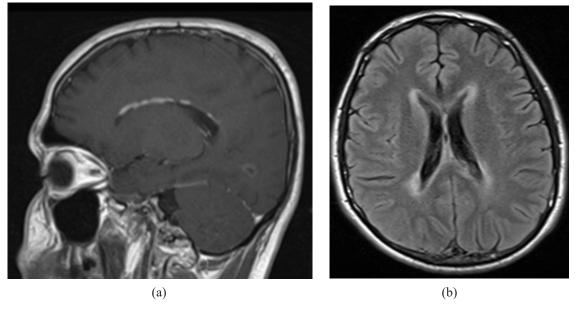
MRI brain and orbits with gadolinium contrast
